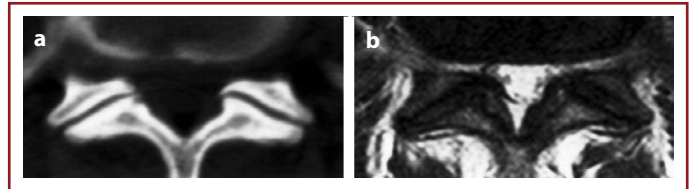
Grade 1 Hypertrophy on the facet joint surfaces on CT and MR images.
